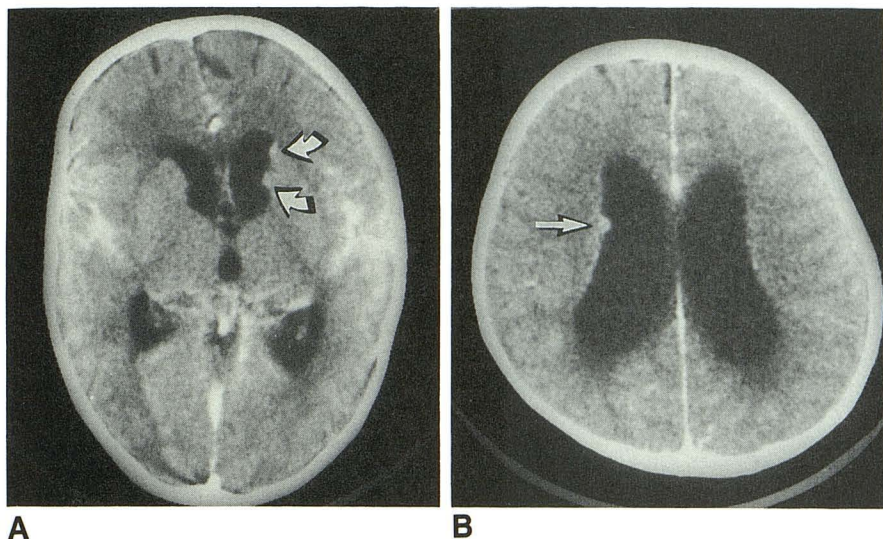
A and B, Postcontrast CT scans show subependymal nodules in frontal horns (A) and body (B) of lateral ventricles (arrows). Ventricular dilatation with mild periventricular lucency is also present.
